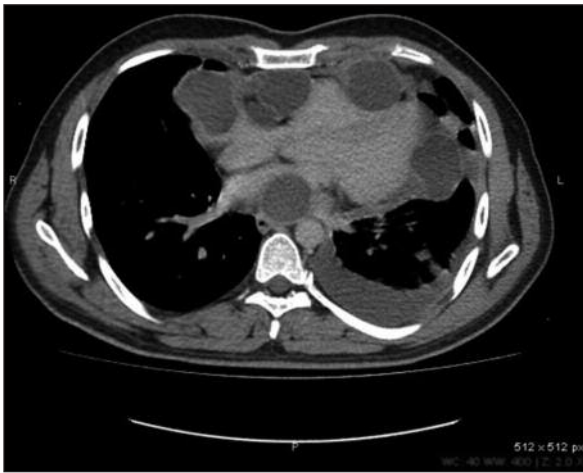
Computed tomography (CT) of the thorax demonstrates multiple cysts surrounding pericardium.
